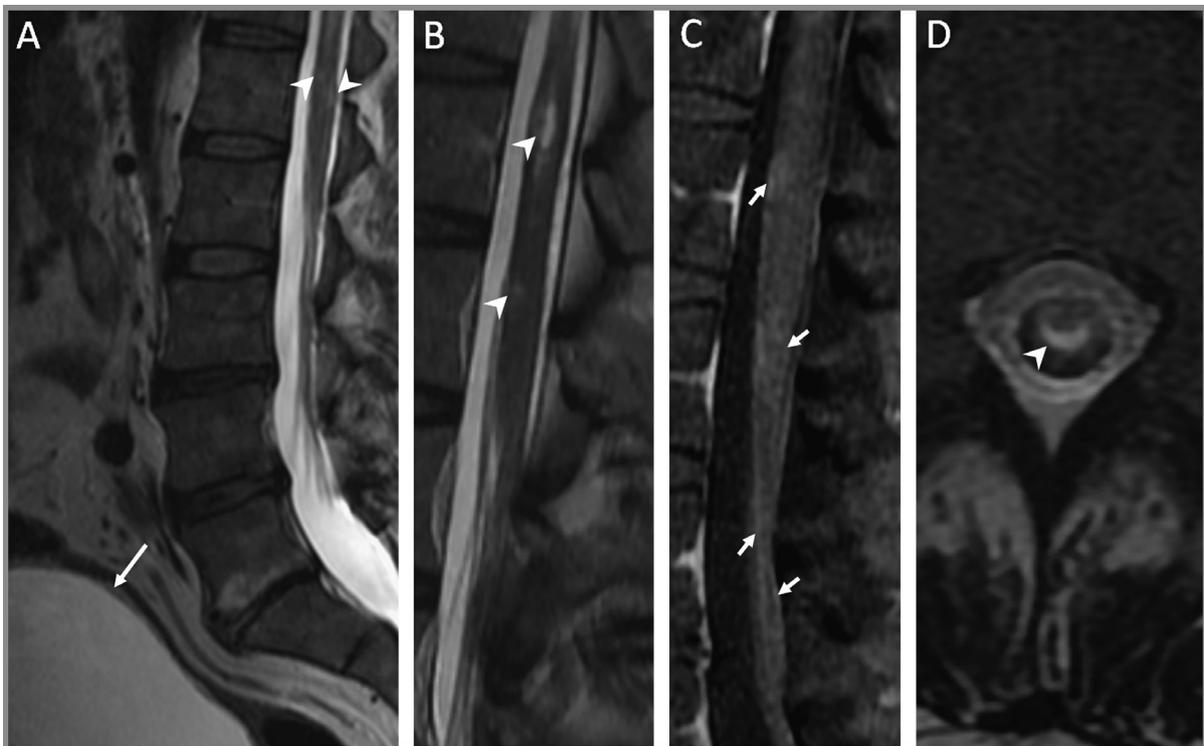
Varicella-zoster virus myeloradiculitis. A, B, D, Sagittal and axial T2-weighted and T1-weighted MRI with contrast of the lumbar spine demonstrates T2 changes intrinsic to the lower spinal cord (arrowheads). C, Patchy enhancement of these intramedullary lesions as well as diffuse root enhancement are evident (arrows). Of note, evidence of severely distended bladder consistent with urinary retention is shown (arrow in panel A).
